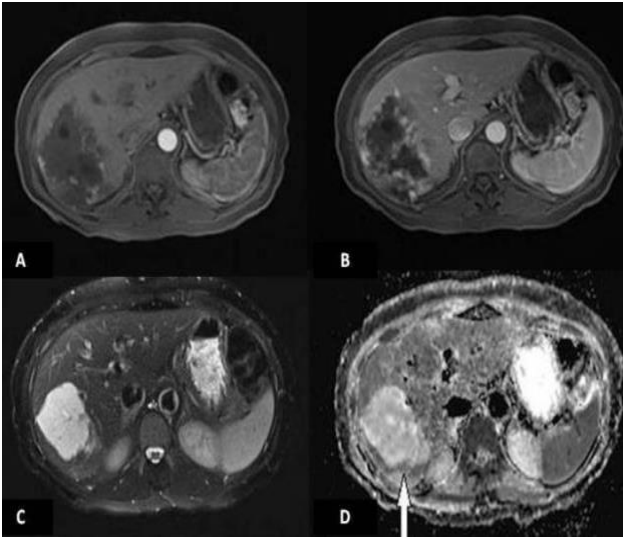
The female patient in 49-year-old. In the dynamic liver MRI of the patient, it is seen that the hemangioma shows peripheral nodular enhancement and progresses towards the center (a, b, c). The giant hemangioma observed in segment 6 in the fat-suppressed T2W image (d) is significantly hyperintense compared to the liver parenchyma. In ADC mapping (e), the mean ADC value of the lesion (arrow) was $1.15 \times 10^{-3} \text{ mm}^2/\text{s}$, while the average ADC values obtained from the healthy liver were measured as $1.02 \times 10^{-3} \text{ mm}^2/\text{s}$.
